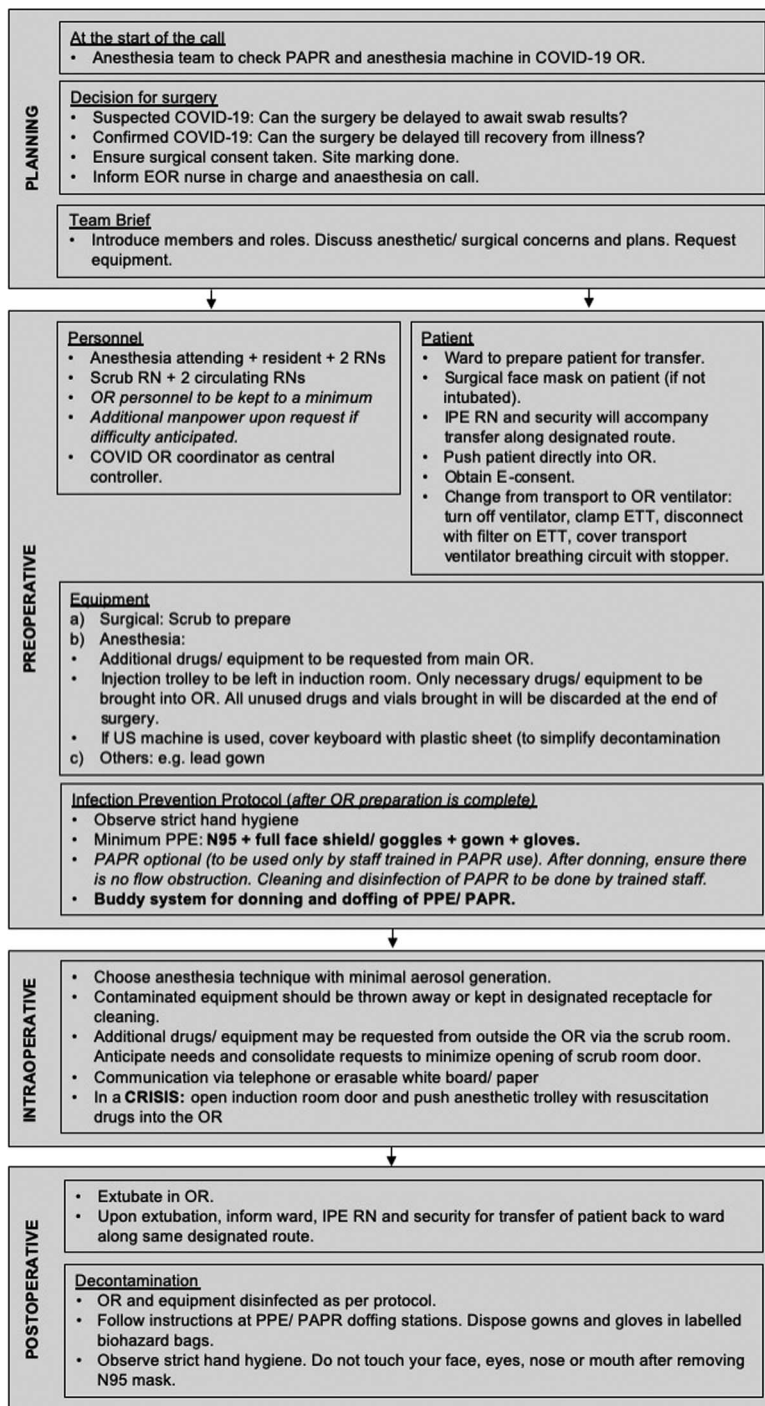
Activation workflow and concept of operations for COVID-19 OR. EOR, emergency operating room; ETT, endotracheal tube; RN, registered nurse; US: ultrasound.
